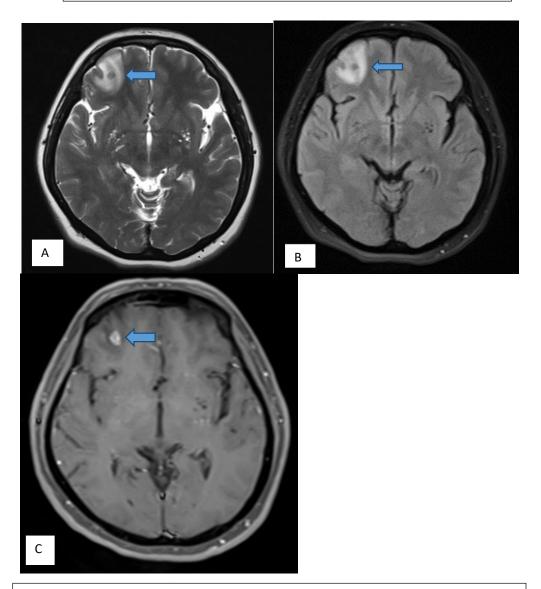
Colloidal vesicular stage of neurocysticercosis (A-C) MRI images (A) Axial T2 WI B) Axial FLAIR images C) Axial T1 W post contrast images: These images show a well-defined T2/ FLAIR hypointense focus (measuring $\sim 6~\text{mm}$) (blue arrows) in right frontal lobe with mild perilesional edema. The lesion shows ring enhancement on post contrast study – Neurocysticercosis (Colloid Vesicular stage).
